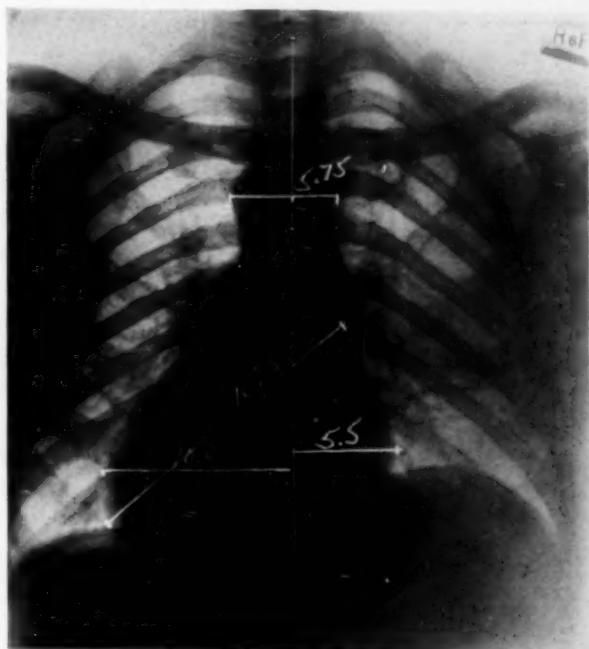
Roentgenogram of chest taken six weeks after operation. Nothing abnormal can be made out. The heart shadow is within normal limits.
